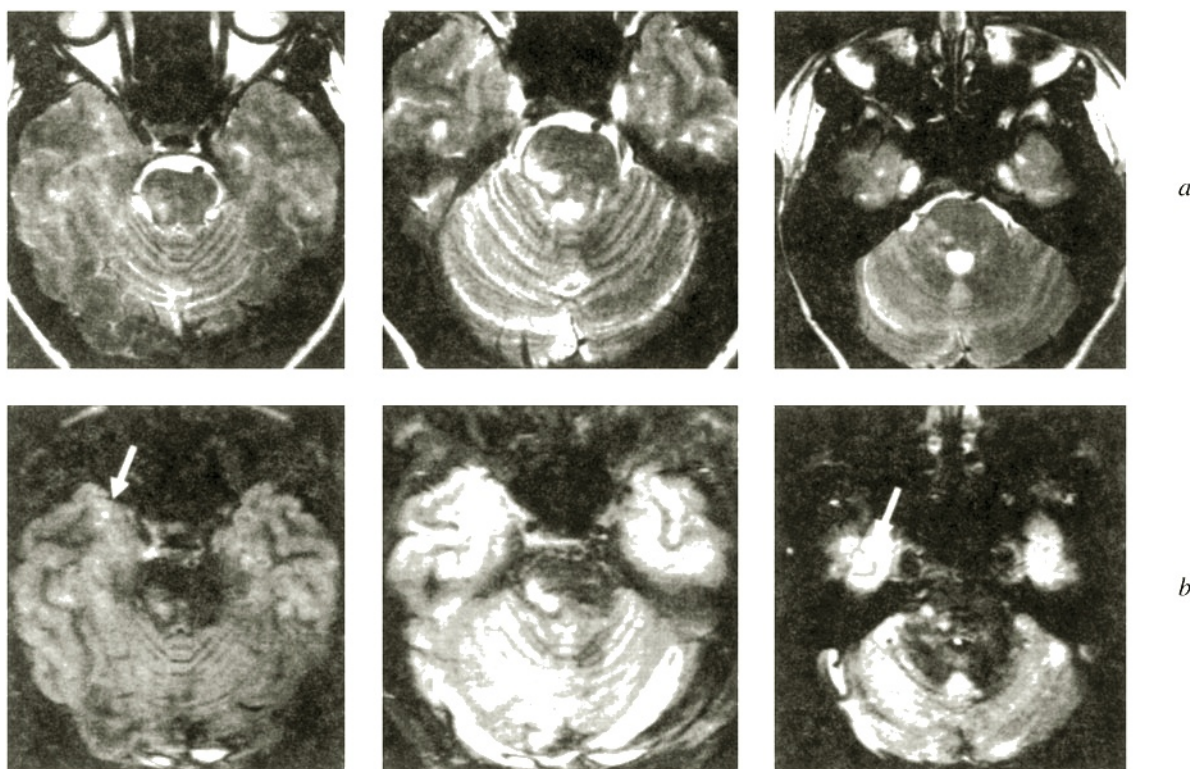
Brain MRI scan in multiple sclerosis with symptomatic epilepsy. Sequence of images in the axial projection: *a*) T2SE shows multiple foci in the pons (mainly on the right) and right temporal lobe; *b*) DIR-GM impulse sequence provides better visualization of foci in the right temporal lobe (arrows) and classifies them as intracortical.
